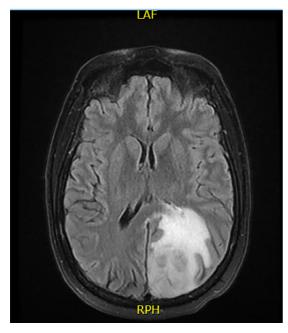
Magnetic resonance imaging (MRI) depicting a multilobulated, peripherally enhancing mass in the left parietooccipital region measuring $3.5 \times 2.8 \times 4.5$ cm with a thick, irregular enhancing rind and extensive surrounding T2/ FLAIR (fluid-attenuated inversion recovery) signal abnormality consistent with an abscess. There is no significant midline shift, herniation, or hydrocephalus.
